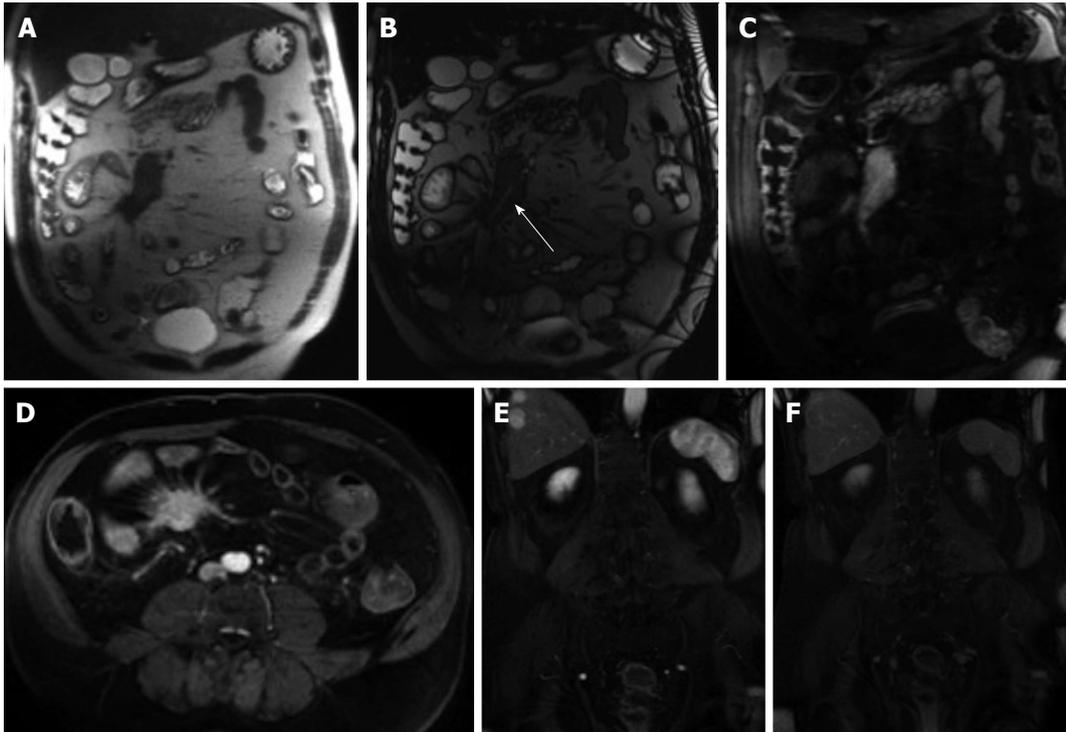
Mesenteric carcinoid. A: Coronal T2-weighted single shot fast spin echo; B: Coronal balanced steady state free precession; C and D: Coronal arterial; E: Axial enteric; F: Coronal interstitial fat-suppressed post-gadolinium 3D-GRE T1-weighted images. There is a large mesenteric mass encasing the superior mesenteric artery and its branches (arrow, B) associated with desmoplastic reaction and small bowel retraction noted on pre-contrast images (A, B), which demonstrates hypervascular (C) and typical sunburst margins (D). Liver metastases are seen with the typical wash-in (D) and washout (F) appearance mimicking the appearance of hepatocellular carcinoma. GRE: Gradient recalled echo.
